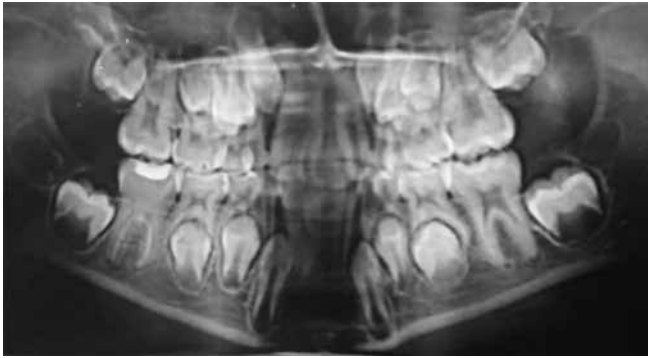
Immediate post-operative radiograph after Portland cement pulpotomy
